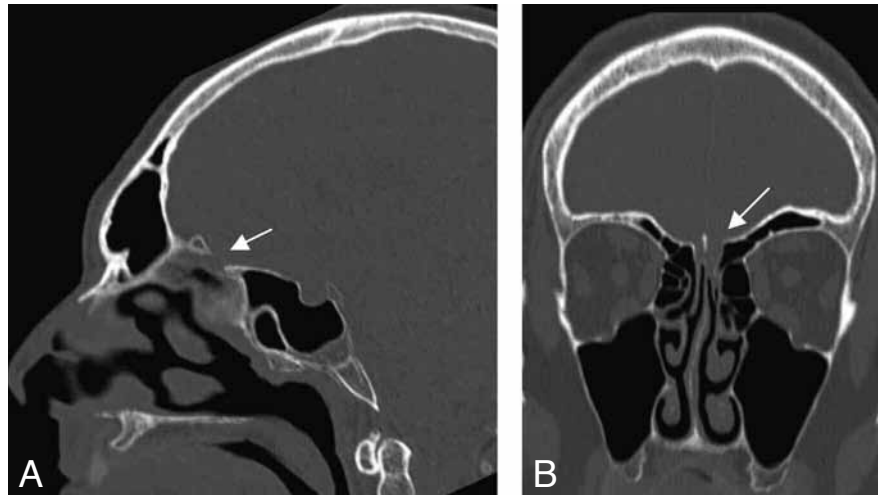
Sagittal (A) and coronal (B) CT slices showing a slight erosion of the cribriform plate and the integrity of the superior nasal cavity (white arrow).
